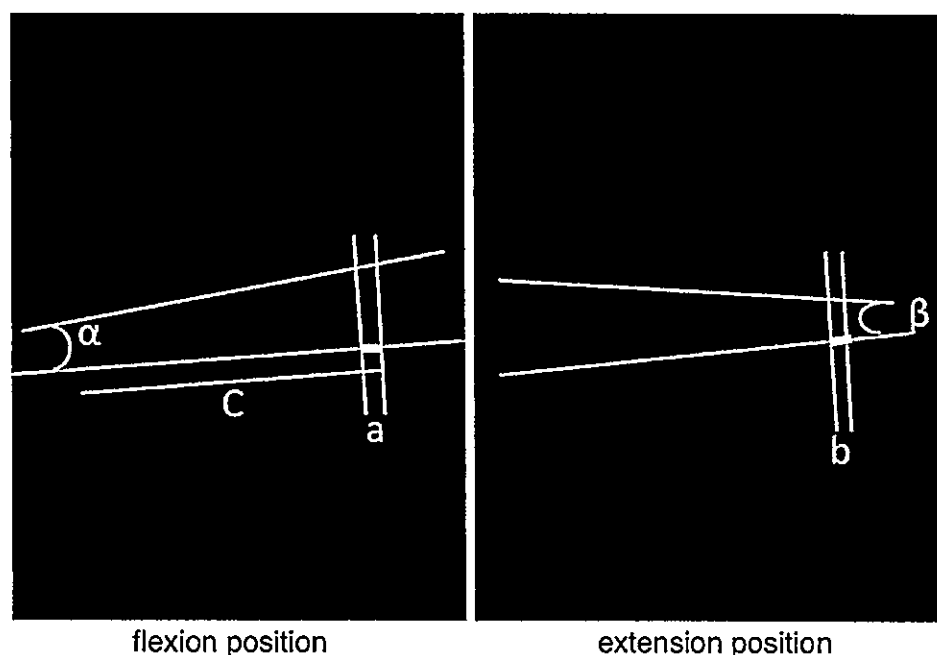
Plain radiography measurement. *a* Anterior slip in the flexion position, *b* posterior slip in the extension position, *c* vertebral body width. The total percent slip is $(a + b)/c \times 100$. α Intervertebral disc
